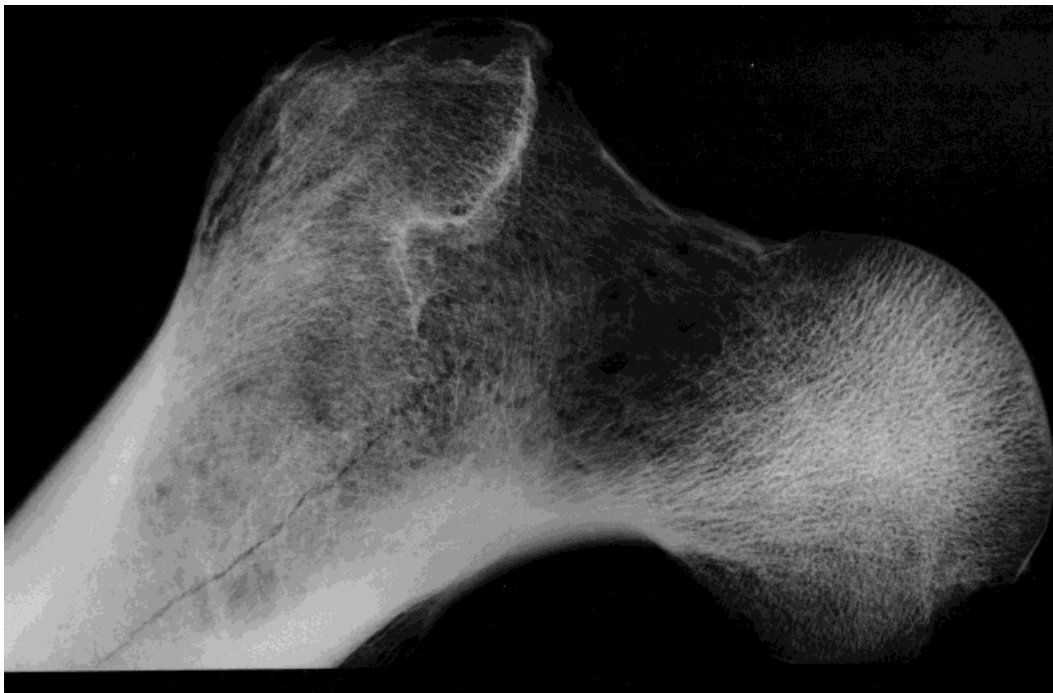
Anterior-posterior x-ray view of proximal femur (HTH 2721). Osteopenia and focal femoral neck lytic areas with slight superior periosteal reaction. Postmortem diaphyseal crack is incidently noted.
